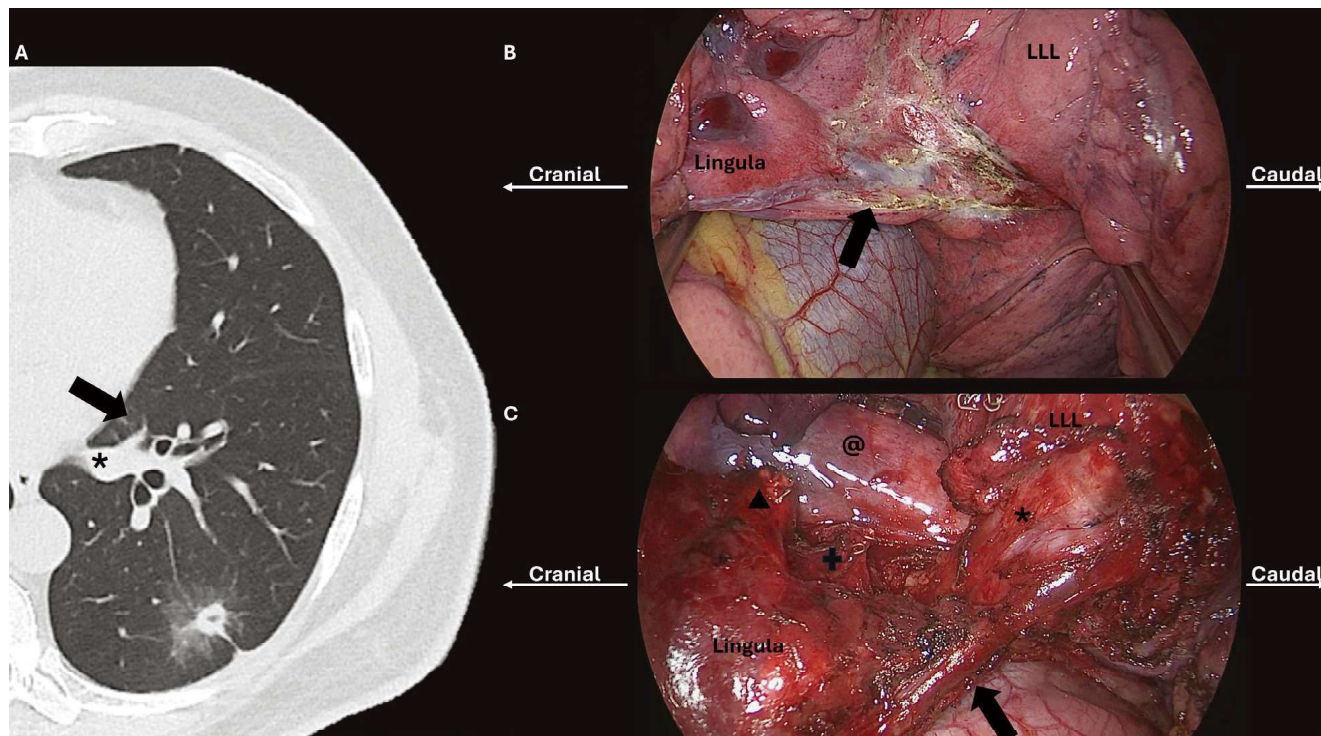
Anomalous left lingular vein. (A) CT images depicting a single tumor located in the left lower lobe of the lung. (B) Identification of the lingular vein during fissure dissection. (C) Thoracoscopic view showing the lingular vein connecting to the inferior pulmonary vein after meticulous dissection. Key symbols: Arrow indicates the lingular vein; "*" represents the inferior pulmonary vein; cross denotes the inferior pulmonary bronchus; LLL signifies the left lower lobe; triangle marks the inferior pulmonary artery; "@" indicates the thoracic aorta.
